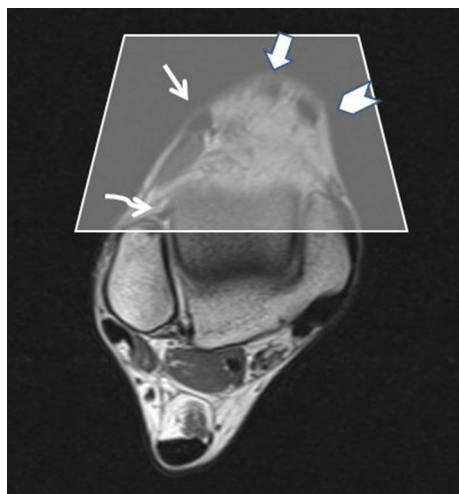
T1-weighted axial MR image showing the anterior compartment, which contains (lateral to medial): the tibialis anterior (*arrowhead*), the extensor hallucis longus (*thick arrow*), and the extensor digitorum comunis (*thin arrow*). The anteroinferior tibiofibular ligament can be seen near the tibiofibular syndesmosis (*crooked arrow*)
